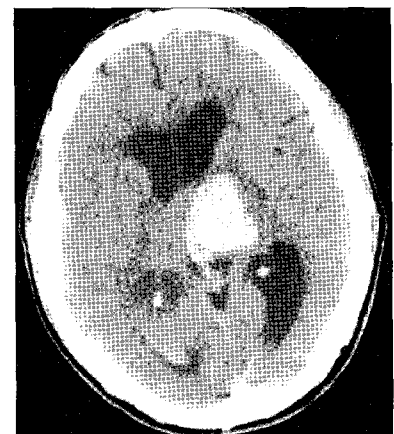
Initial computed tomography shows intracranial hemorrhage in the left thalamus and both lateral ventricles.
